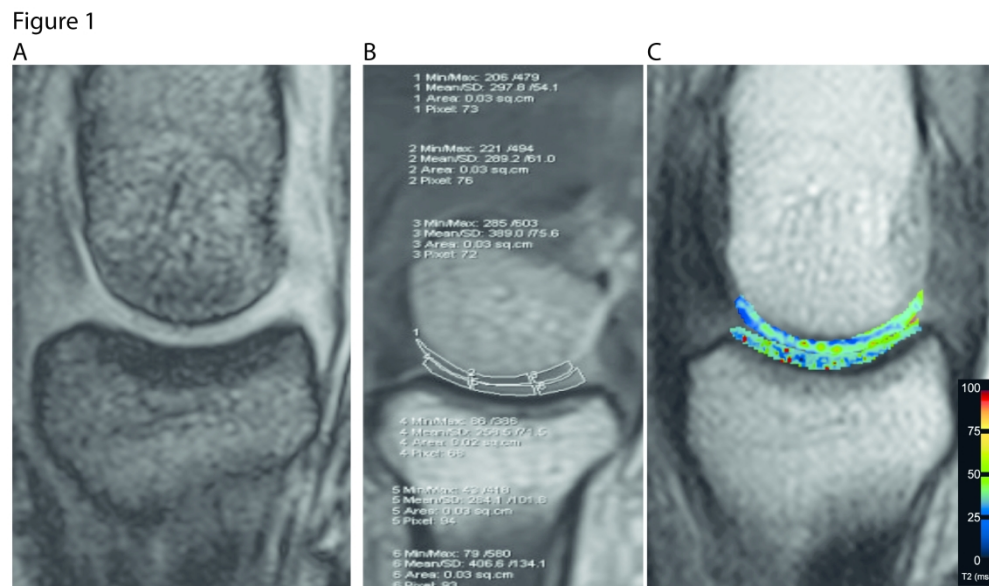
3 Tesla Magnetic Resonance Imaging with T2 Mapping(A) Enlarged morphological image of metacarpophalangeal joint 2; (B) Articular cartilage of the metacarpophalangeal joint was divided in six regions of interest (ROI; medial, central and lateral region of the metacarpal head and the phalangeal base, respectively). (C) T2 map (hybrid image) composed of the regional T2 relaxation times of metacarpophalangeal joint cartilage.
